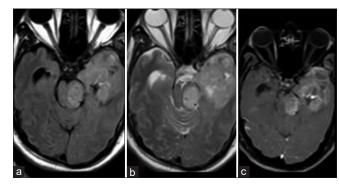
Sequential axial FLAIR (a), T2-weighted (b) and post-contrast T1-weighted (c) MRI done after 3 weeks showing a further increase in the area of involvement of the abnormal high signal intensity in the left temporal, left parietal lobes extending in the brain stem with mass effect. Heterogeneous mass-like enhancement is seen on post-contrast images FLAIR = Fluid-attenuated inversion recovery; MRI = Magnetic resonance imaging
